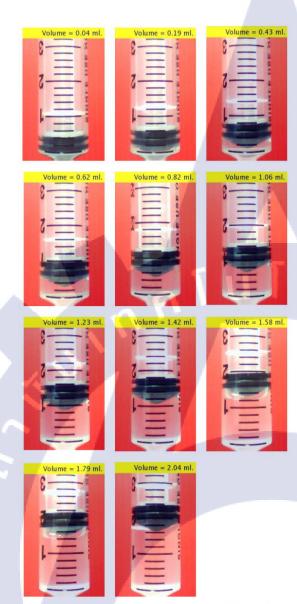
Photographs of a 5-ml syringe that is visible for the operator at different level of dispensing [¹⁸F]-FDG with a step of 0,2ml.
